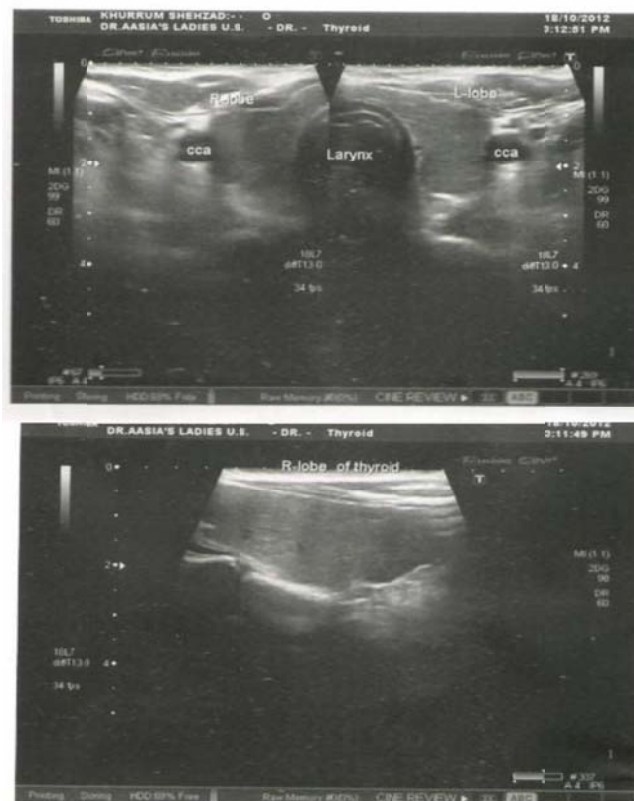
A & B. Ultrasound picture of parathyroid Adenoma
